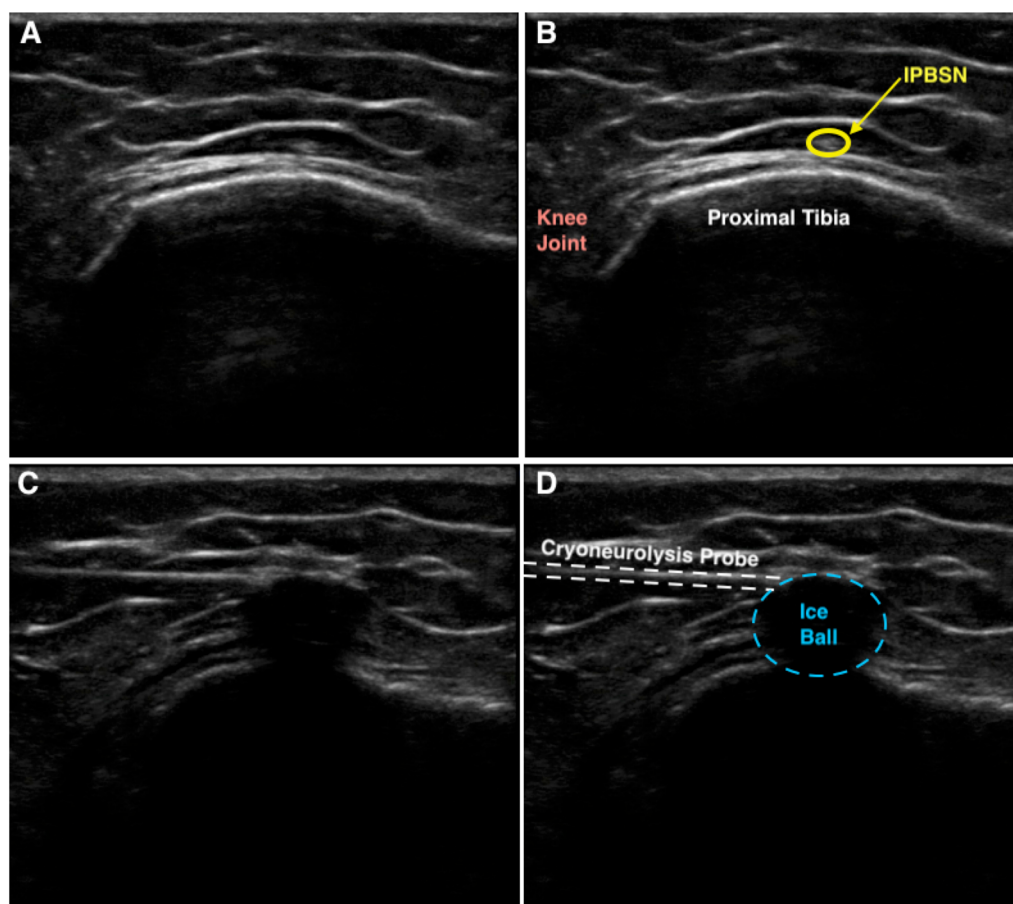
Ultrasound images of percutaneous cryoneurolysis of the infrapatellar branch of the saphenous nerve (used with permission from Matthew W. Swisher, MD, MS)
